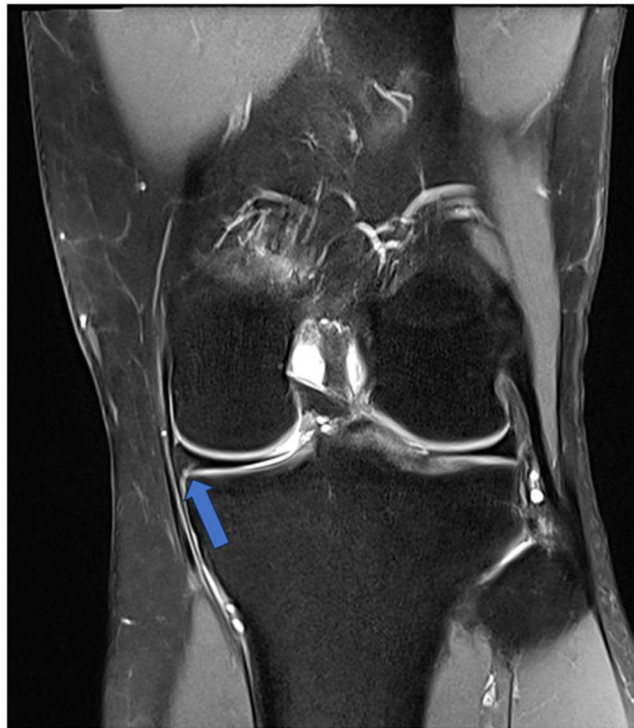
Coronal T2-weighted fat-suppressed magnetic resonance imaging (MRI) of the left knee. The blue arrow indicates a hyperintense linear signal at the posterior horn of the medial meniscus, consistent with a partial tear. The medial meniscus appears irregular in contour, suggesting degenerative changes and fiber disruption without complete detachment. Surrounding soft tissue structures, including the pes anserinus region, show no direct involvement on this slice.
